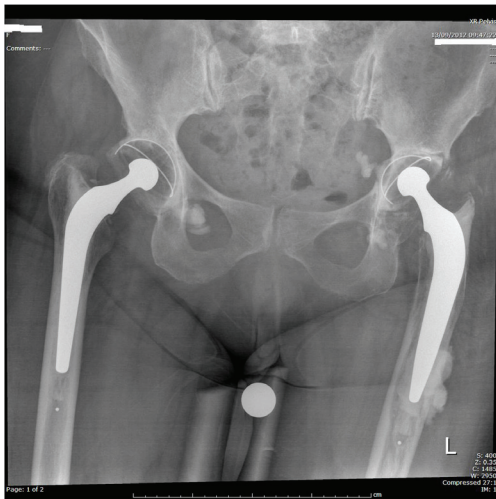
Pelvic X-ray 6 months after initial presentation.
